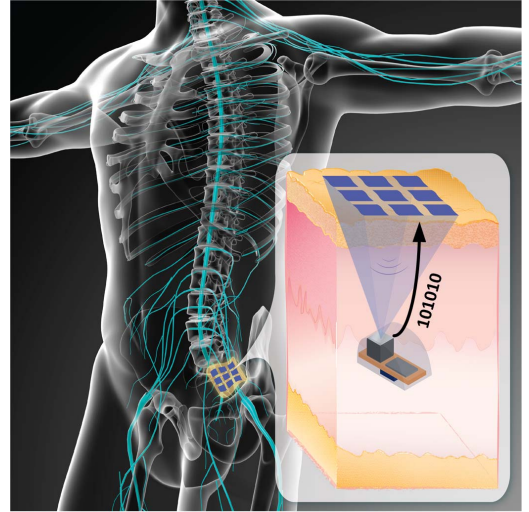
Conceptual image of fully ultrasonic implantable pressure sensor system.
